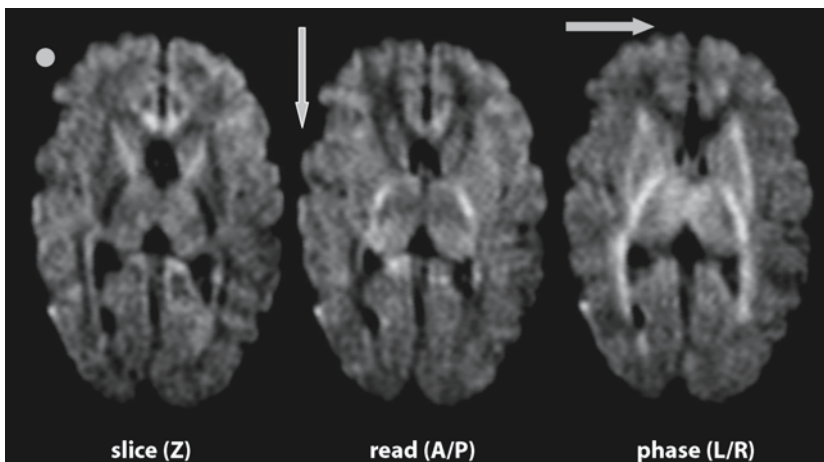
Diffusion-weighted-imaging (DWI) and diffusion tensor imaging (DTI) allow further refinement and quantitation of the progress of myelination. These images depict single-shot EPI with single diffusion gradient in slice, read or phase direction at $b=1000$, showing anisotropy of myelinated fibers depending on the gradient direction in a baby boy 3 months of age
